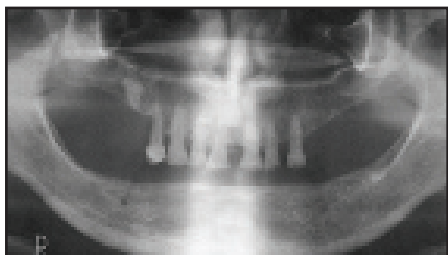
The preoperative panoramic radiograph of patient no. 2
